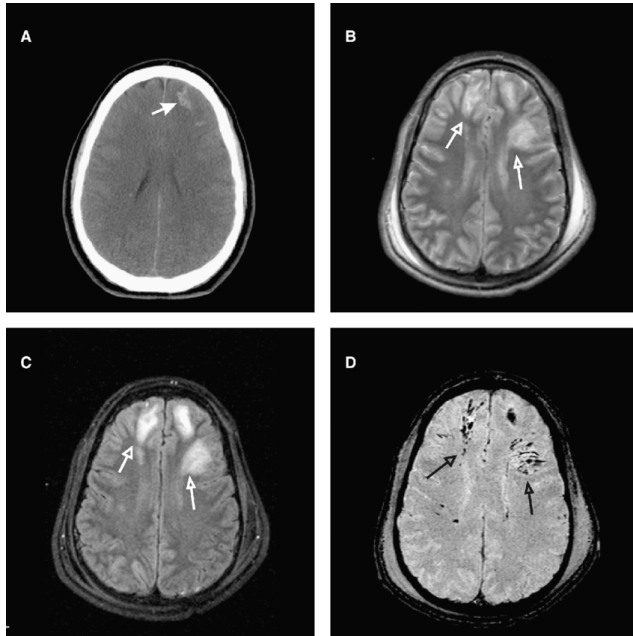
CT, T2, FLAIR, and SWI (A, B, C, and D, respectively) of a 40-year-old male who suffered a [TBI](#). CT demonstrates an ill-defined haemorrhage in the left frontal lobe (solid white arrow). T2 and FLAIR show a large lesion in the left frontal lobe and a smaller lesion in the right frontal lobe (open white arrows). While T2 and FLAIR show large areas of injury, SWI demonstrates numerous smaller foci of haemorrhage. SWI particularly identifies traumatic haemorrhage at the frontal gray-white matter junction that may be associated with diffuse axonal injury (open black arrows) [\[80\]](#).
